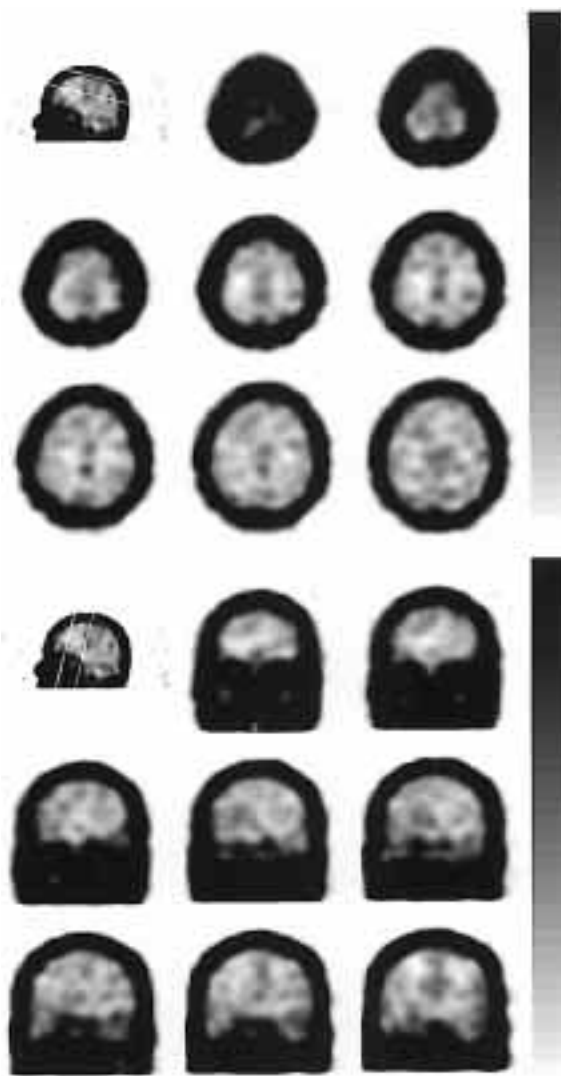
^{201}Tl scintigraphy of the head. The abnormal accumulation is found to have disappeared.
